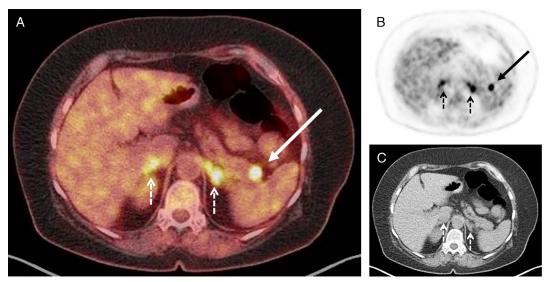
Here, we report on a 68-year-old woman with new-onset hypertension (>200/90 mm Hg) who was referred to our institution with suspicion of ectopic ACTH syndrome (EAS) for further work-up. ACTH and cortisol levels were highly increased; the dexamethasone suppression test was negative. Sinus petrosus catheterization confirmed EAS. No ectopic source was detected by CT and MRI. Combined ¹⁸F-FDG PET/CT (A) as a whole-body imaging modality revealed an intense hypermetabolic focus in the pancreatic tail (*arrows*, A and B). Additionally, due to continuous ACTH stimulation, both hypertrophic adrenals showed reactive FDG uptake (*dotted arrows*, A–C). Surgical exploration was performed and revealed a 9-mm-sized, well-differentiated neuroendocrine tumor of the pancreatic tail with ACTH production which was removed in toto. Serum ACTH levels normalized within 24 hours.
